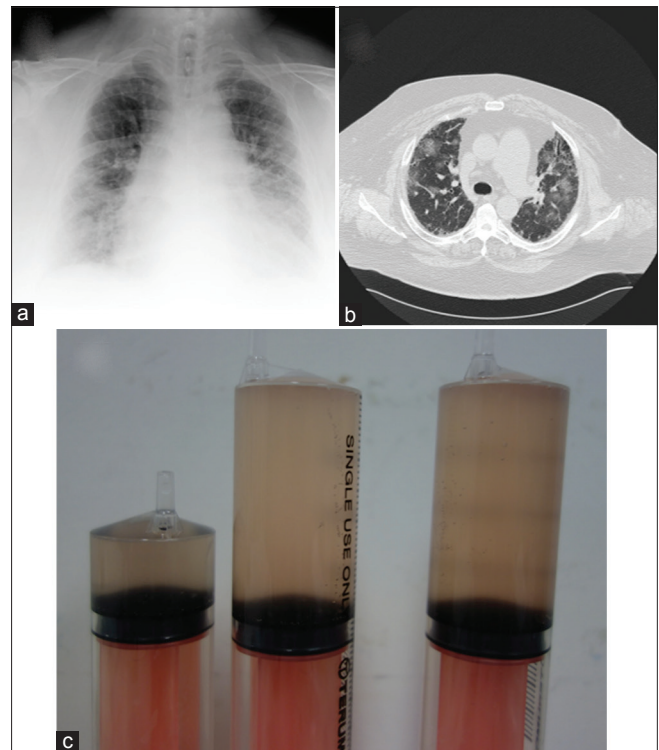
(a) Chest X-ray and (b) computed tomography revealing bilateral diffuse infiltrative and ground-glass opacities. (c) Macroscopic bloody appearance of bronchoalveolar fluid
